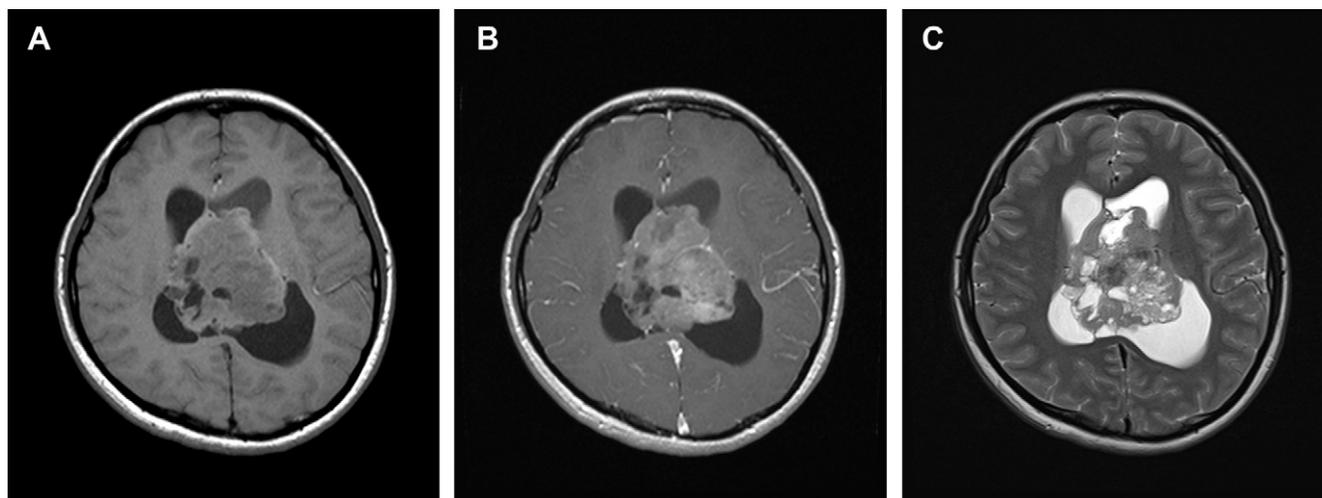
(A) Axial noncontrast-enhanced and (B) contrast enhanced T1-weighted and (C) T2-weighted magnetic resonance images reveal a large, isointense, heterogeneous intraventricular mass originating from the septum pellucidum with broad base attachment to the body of the lateral ventricles. There is a mild degree of contrast enhancement of the solid portion of the tumor. Numerous cystic spaces within the tumor are also seen.
